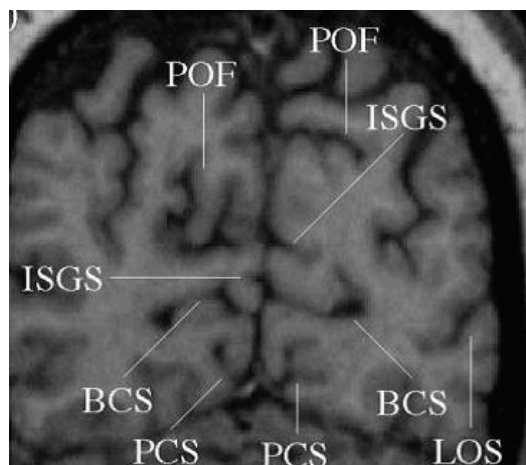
Coronal sections of the occipital lobe through the magnetic resonance imaging volume (patients)(Mašić R./Institutzaradiologiju UKCS, 2013)
